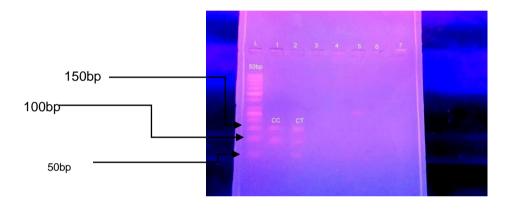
Restriction fragment length polymorphism assay for single nucleotide polymorphism rs12979860.Lane 1, 50bp ladder, Lane 1, 2 shows the two different alleles for rs12979860, (1) CC=100 and 150bp, (2) CT=50,100and 150
